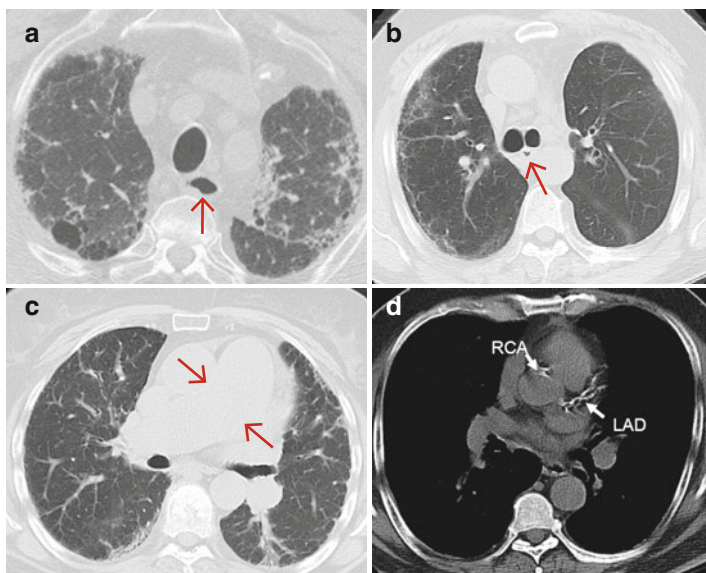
Extra-pulmonary structures to evaluate on computed tomography scans: (a) patulous esophagus, (b) thickened esophagus, (c) enlarged pulmonary artery (*red arrow*), and (d) coronary artery calcifications. *LAD* left anterior descending artery, *RCA* right coronary artery
